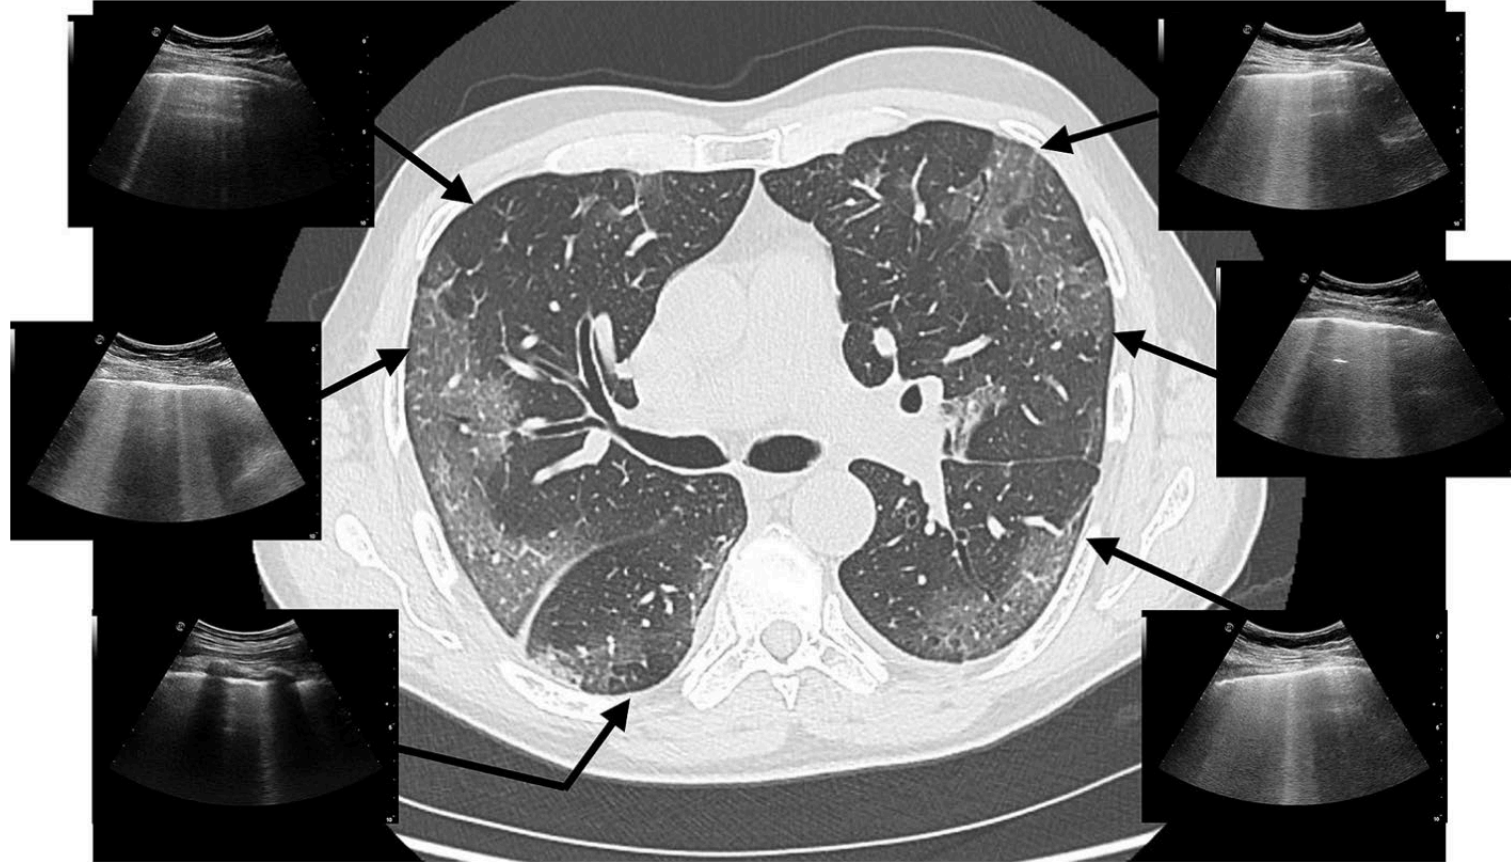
The case of a 65-year-old patient complaining of fever, cough, and fatigue for 4 days, without signs of respiratory failure and showing normal saturation in room air. The CT scan shows bilateral early smooth GGO affecting main part of the lung periphery. The correspondent LUS exam shows the typical interstitial signs with patchy distribution well characterized by the "light beam" in abrupt alternance with "spared areas". *CT* computed tomography, *LUS* lung ultrasound, *GGO* ground-glass opacity
